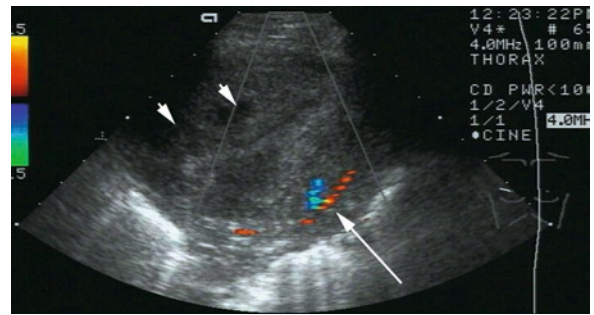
(a) Supraclavicular lymph node metastases in a woman with a bronchial adenocarcinoma. (b) Diffuse metastatic invasion of the entire right lobe of the liver in a man with a non-small-cell lung carcinoma. (c) This 69-year-old man with a known right-sided adenocarcinoma and mediastinal lymphomas developed a swelling in the right arm. Sonographic investigation from the right supraclavicular aspect shows a recent thrombosis subclavian vein
